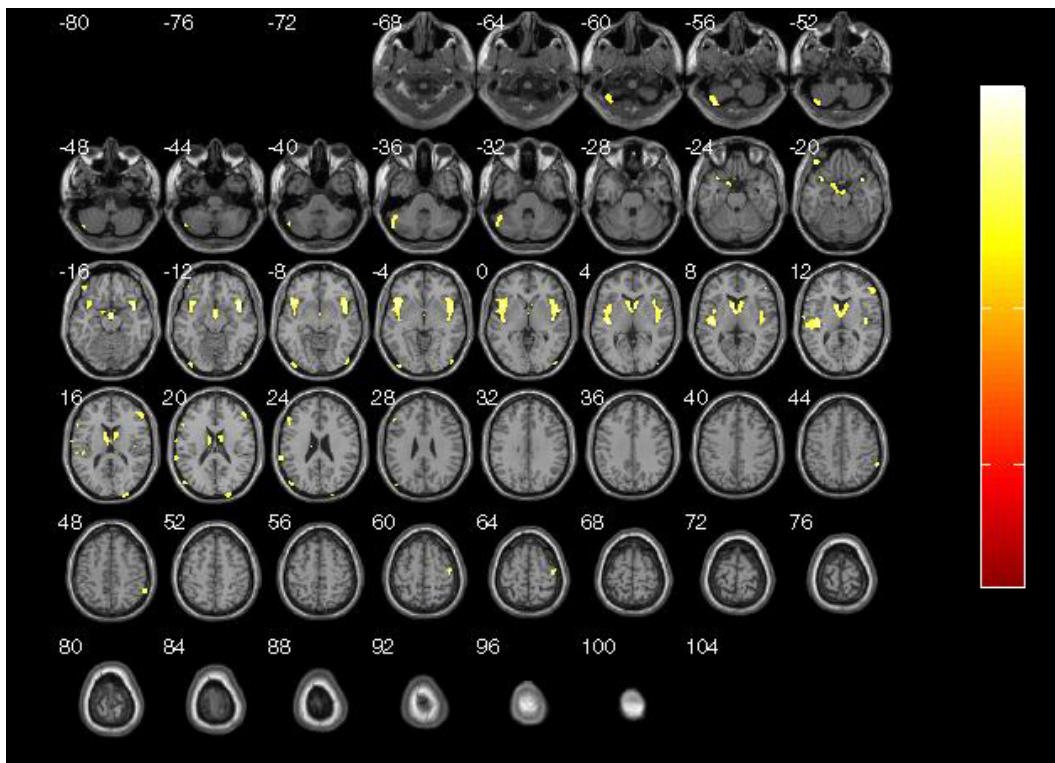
Parametric mapping of grey-matter loss in DM2 compared to control (T1-weighted scans).*
